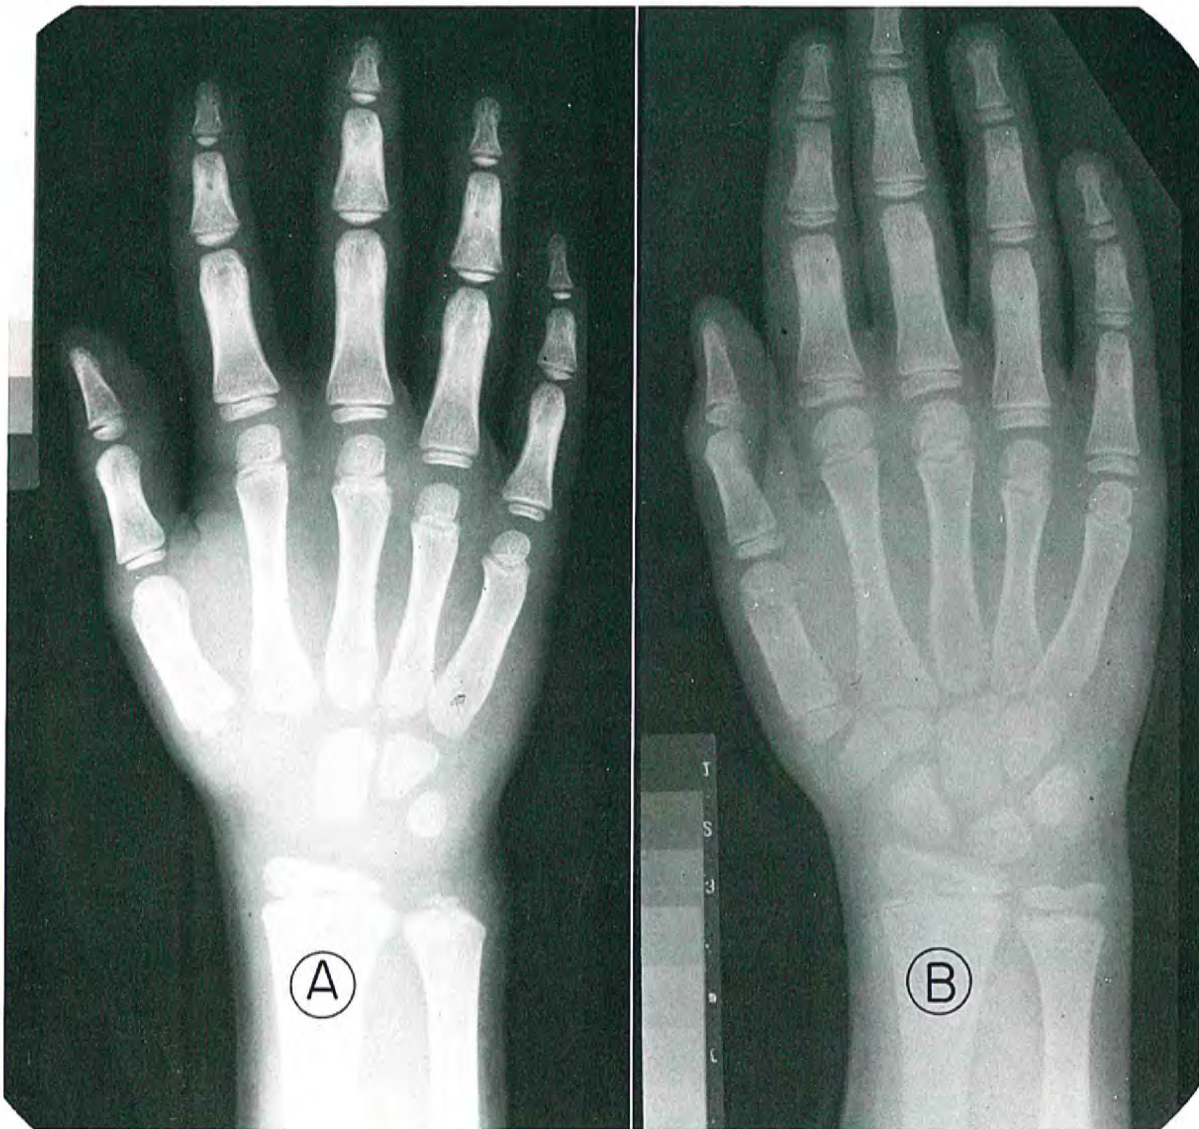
Wrist radiographs of one individual with a delayed maturational pattern (A) and another of similar chronologic, but advanced skeletal, age (B).
